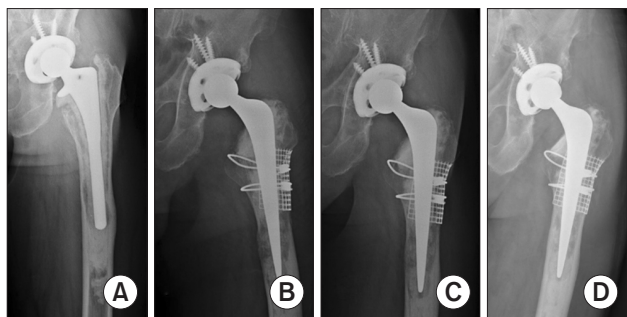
(A) Preoperative radiograph of a 64-year-old man who showed aseptic loosening and osteolysis in all femoral zones and extending into the diaphysis. (B) Postoperative radiograph of femoral reconstruction using a mesh and an impacted cancellous allograft with a standard cemented stem. (C) Radiograph at 3 months postoperative showing trabeculation and cortical bone repair. (D) At 13 years, radiograph showing 2-mm subsidence, trabecular remodeling of the grafts, no loosening, no osteolysis.
